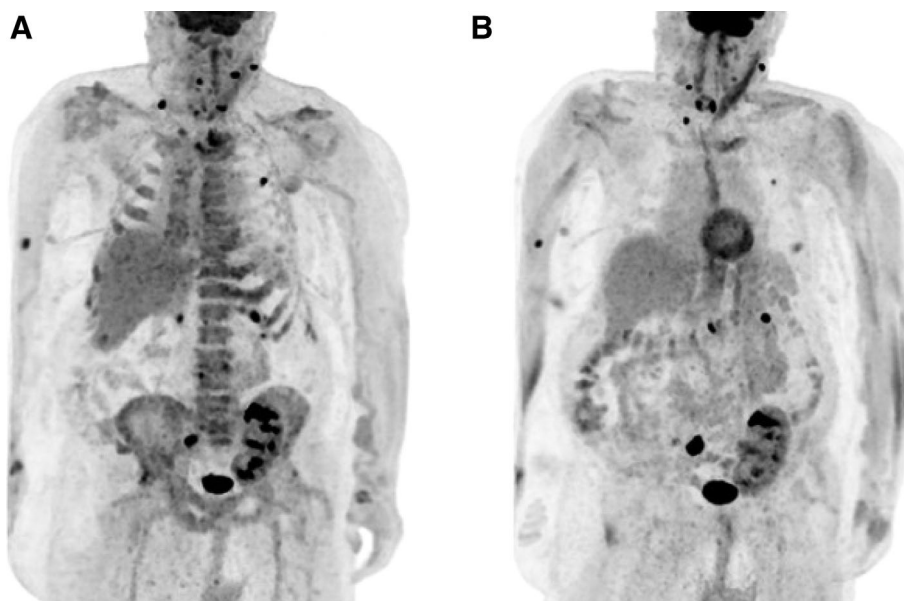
Radiological course of lesion in the second case in coronal view. Coronal maximum-intensity projection image from baseline (A) and follow-up (B) positron emission tomography/computed tomography show an overall decrease in multiple fluorodeoxyglucose-avid lesions.
